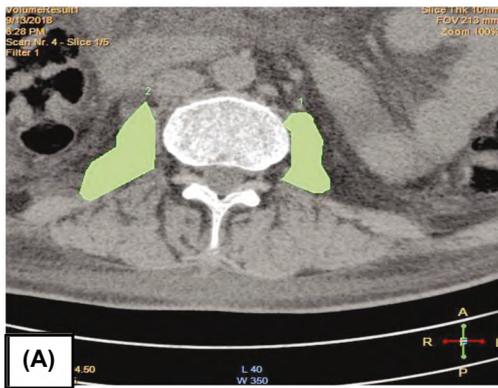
Mean of CT psoas muscle volume, surface area and psoas index.
